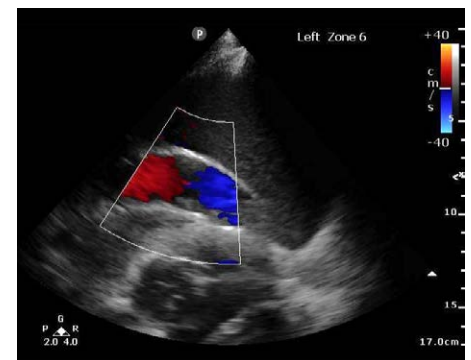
Left posterior lung ultrasound with Doppler
